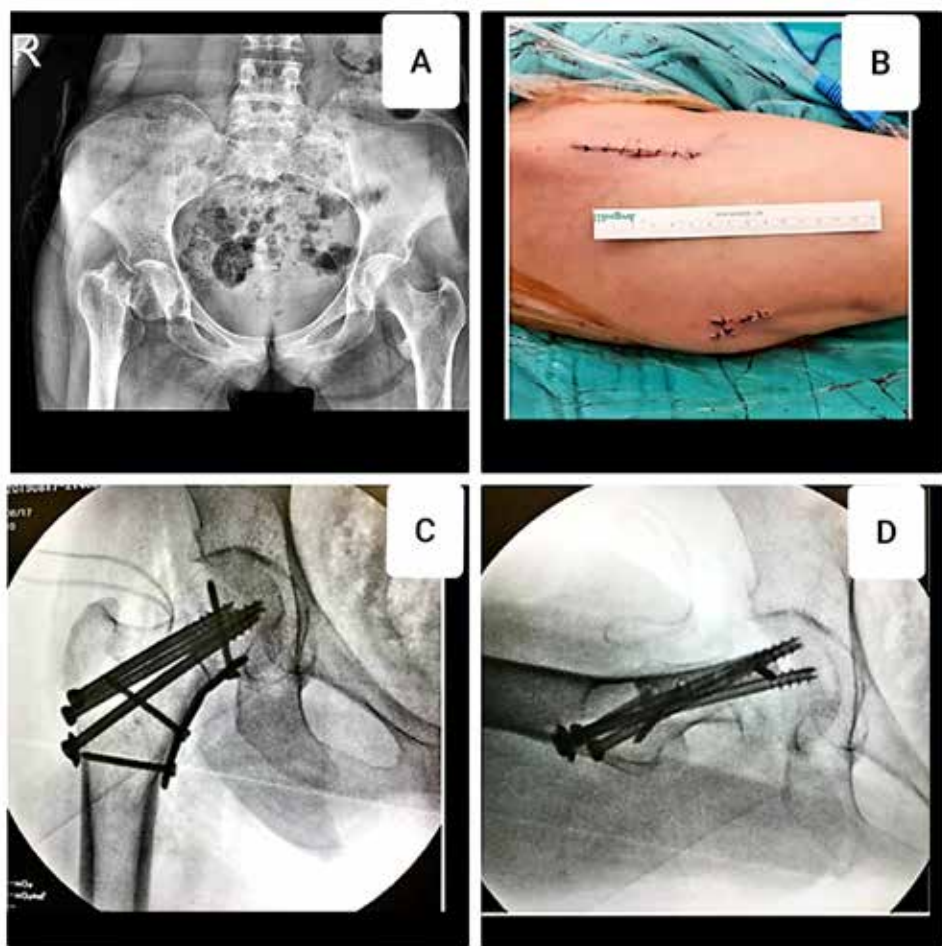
A) Preoperative AP pelvis radiograph. B) Postoperative surgical incisions of the patient. Intraoperative fluoroscopy images of the patient; C) Anteroposterior, D) Figure four position image.
